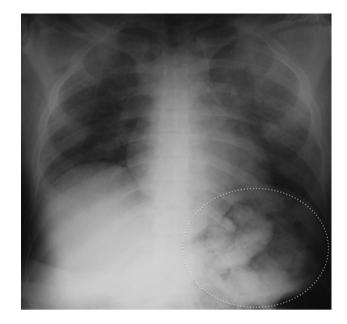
Postmortem supine plain chest X-ray. No pneumothorax or pleural effusion was detectable. Note the bilateral pulmonary edema. In the projection over the stomach, there are multiple suspicious round and oval shaped radio-opacities that were diagnosed as body packs (*white dotted circle*)
